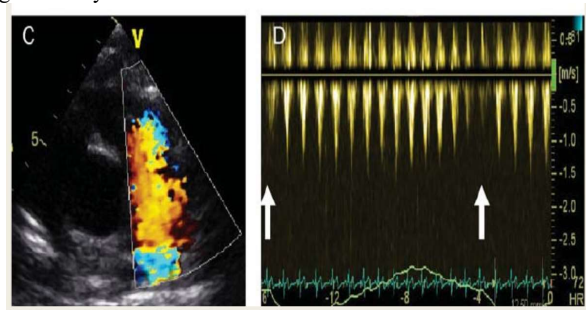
Colour Doppler mosaic pattern in the right ventricular outflow
